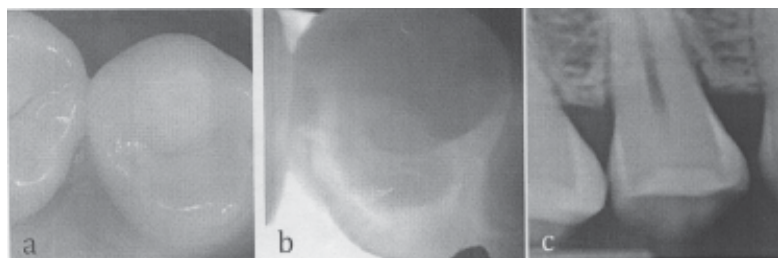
The clinical aspect (a), the DIAGNOcam image (b) and the radiographic image (c) of the tooth 1.4. distal
